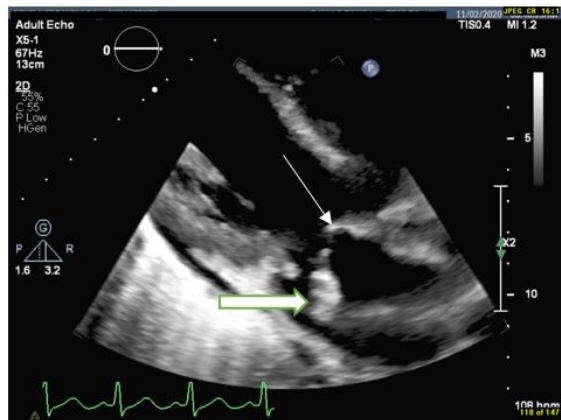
Transthoracic parasternal view depicting anterior mitral leaflet (thin white arrow) and large vegetation attached to it (thick white arrow).
